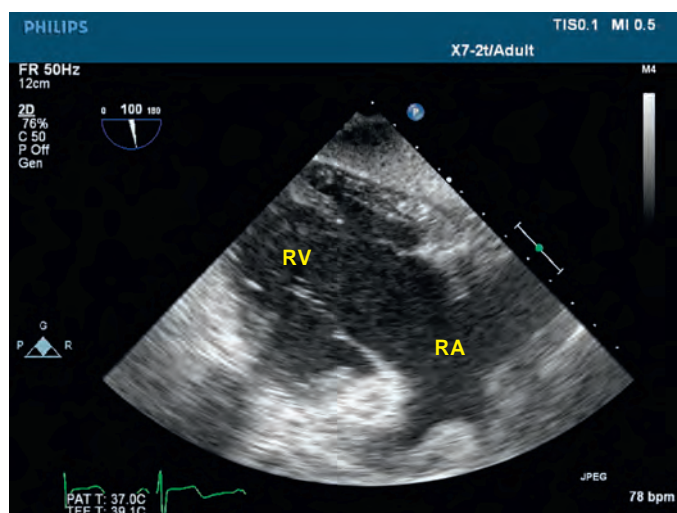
Modified transgastric right ventricular inflow view obtained by deeper insertion and antelexion of the transesophageal echocardiography probe from the conventional transgastric right ventricular inflow view, offers improved alignment with the tricuspid annulus for M-mode and tissue Doppler imaging interrogation. RA, Right atrium; RV, right ventricle. (Video clip available online.)
